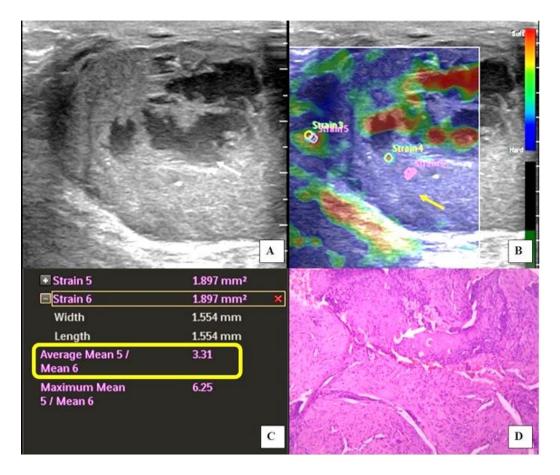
Ultrasonography in 35-year female patient showed a well-defined, lobulated, ovoid, hypoechoic solid lesion with central necrosis (thin white arrow) and posterior acoustic enhancement, possibly breast abscess (Fig A). Elastography (Fig B & C), showed features of malignancy with uniform pattern (score 2) of blue (thick yellow arrow) and mean strain ratio of 3.31 (white box). Ultrasound guided core needle biopsy (Fig D) revealed islands of squamous epithelium (thick short white arrow) with dyskeratosis, in a fibrous stroma suggestive of squamous cell carcinoma.
